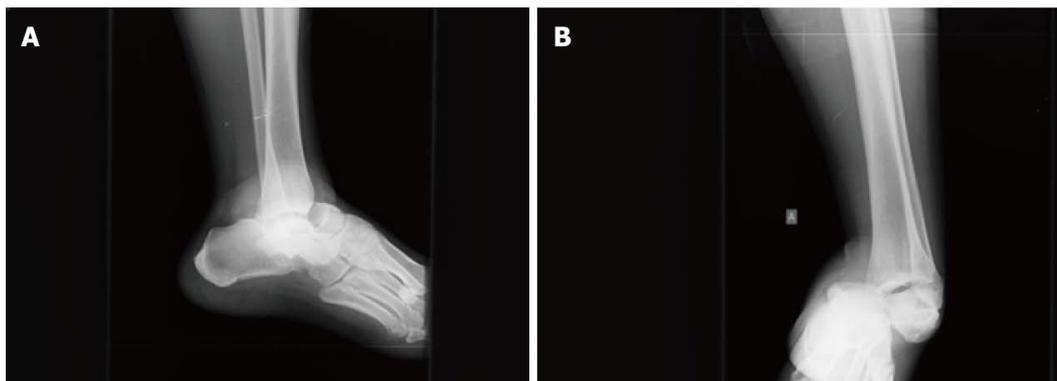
X-rays of the left ankle. Dislocation of the talonavicular and talocalcaneal joints with no obvious fracture is shown. The calcaneus is displaced in medial position in the anteroposterior view. A: Lateral view; B: Anterior posterior view.
